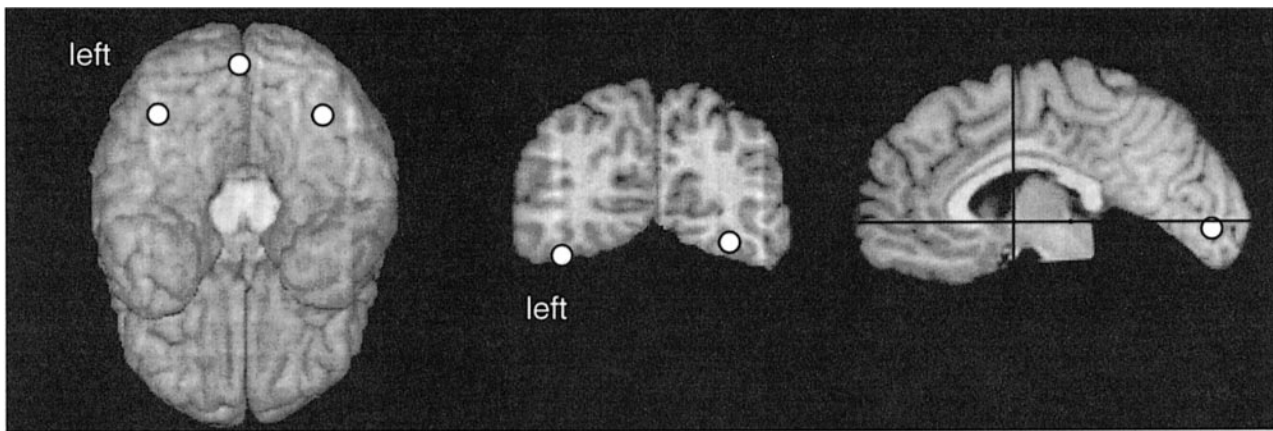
Average locations across subjects for the MO-, ROT- and LOT-ECDs. (Left) Sources projected on a view of the cerebrum from below (left on left, occipital pole up). The cerebellum has been removed from this MRI surface reconstruction. (Middle) ROT and LOT source locations shown on a coronal MRI slice 65 mm posterior to the anterior commissure. (Right) MO source location on a midsagittal slice. The white vertical line indicates the location of the coronal slice, while the black lines show the Talairach coordinate system axes. After normalization of the brains (Talairach and Tournoux, 1988), the MO sources ($n = 10$) were located at the Talairach coordinates: -2 ± 6 , -86 ± 6 , -3 ± 12 (mean \pm SD, distance in mm to the right of midline, anterior to the anterior commissure, and above the anterior commissure–posterior commissure plane). Similarly, the Talairach coordinates of the ROT sources ($n = 9$) were $+35 \pm 8$, -64 ± 10 , -8 ± 5 , and those of the LOT sources ($n = 7$) were -38 ± 7 , -65 ± 12 , -14 ± 7 .
